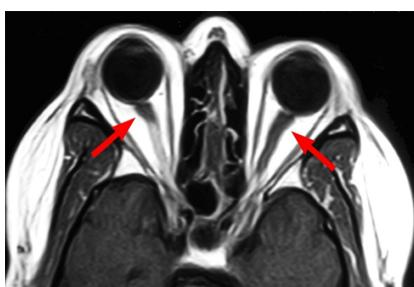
Cerebral MRI, T1 post-contrast image in axial view shows enhancement of the intra-orbital segment of the optic nerves, bilaterally (arrows).
